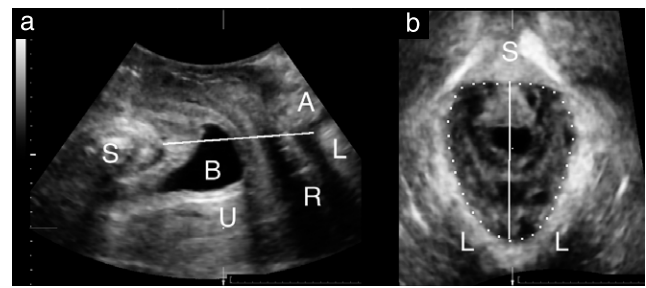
Translabial ultrasound images showing determination of the plane of minimal hiatal dimensions on Valsalva maneuver in mid-sagittal (a) and axial (b) planes. Location of this plane is indicated by oblique line in (a) and vertical line in (b). A, anal canal; B, bladder; L, levator ani; R, rectal ampulla; S, symphysis pubis; U, uterus.
